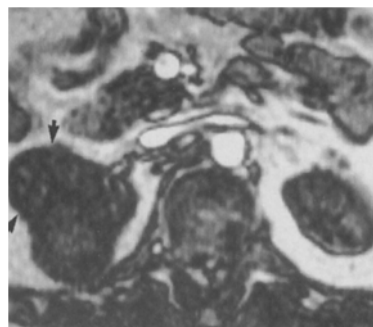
Low flip angle gradient-recalled echo (30° flip angle, $TR = 9.0$, $TE = 2.5$) MRI showing the patency of the IVC in a patient with a right upper pole renal carcinoma (*arrows*)
